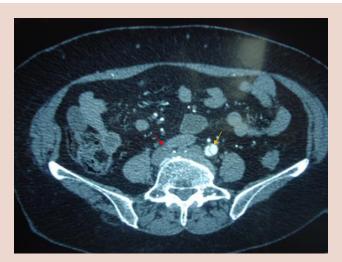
Reconstruction of Aortic CT-Scan showed the dissection.
